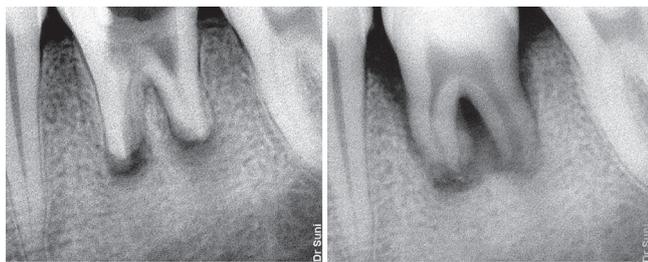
Pre operative radiograph of 36; Figure-2: Post operative - 3 month follow up
